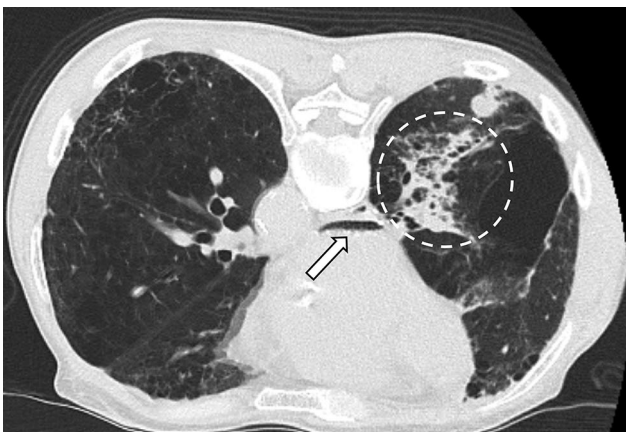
A computed tomography image at 4 h after lung biopsy. The amount of air in the left atrium is decreased, but still remains (arrow). Infiltrative opacity is improved (circle).
